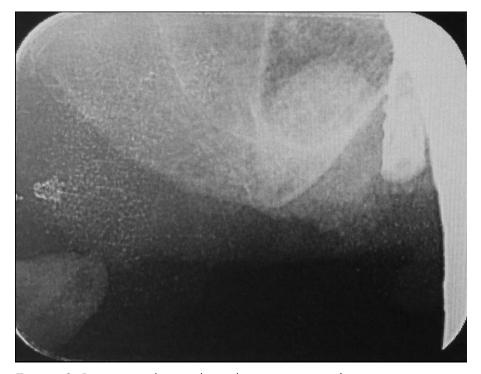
Post-op radiograph to document crestal sinus augmentation.
